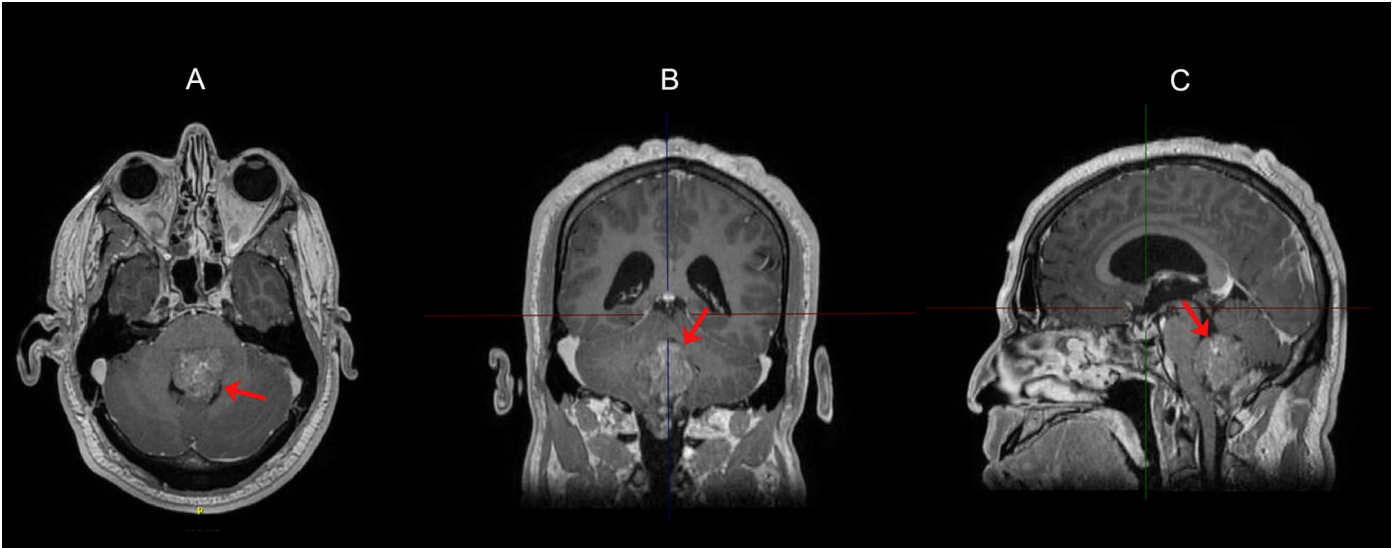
Final preoperative T1 MRI imaging of the head in a) axial, b) coronal and c) sagittal orientations. Ependymoma filling the fourth ventricle is indicated by the red arrow.
